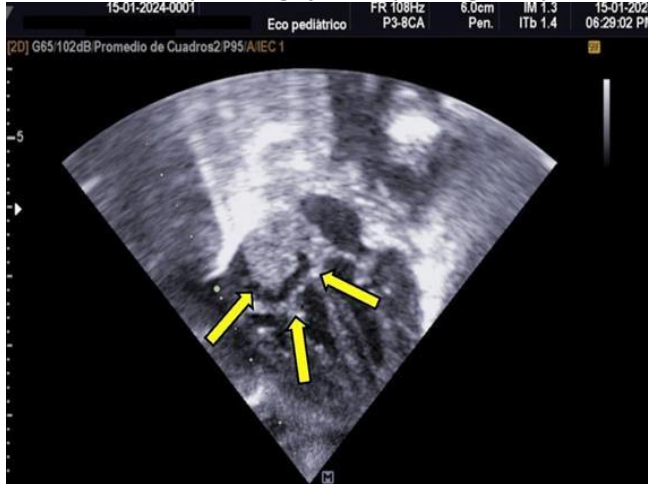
Transthoracic echocardiogram, apical 4-chamber view. Appearance of a recurrent thrombus, 1.5×1.8 cm, adhered to the interatrial septum, with a hyperechoic appearance and systolic mobility, detected days after the initial resolution. This finding suggests an early recurrence despite the ongoing anticoagulant treatment.
